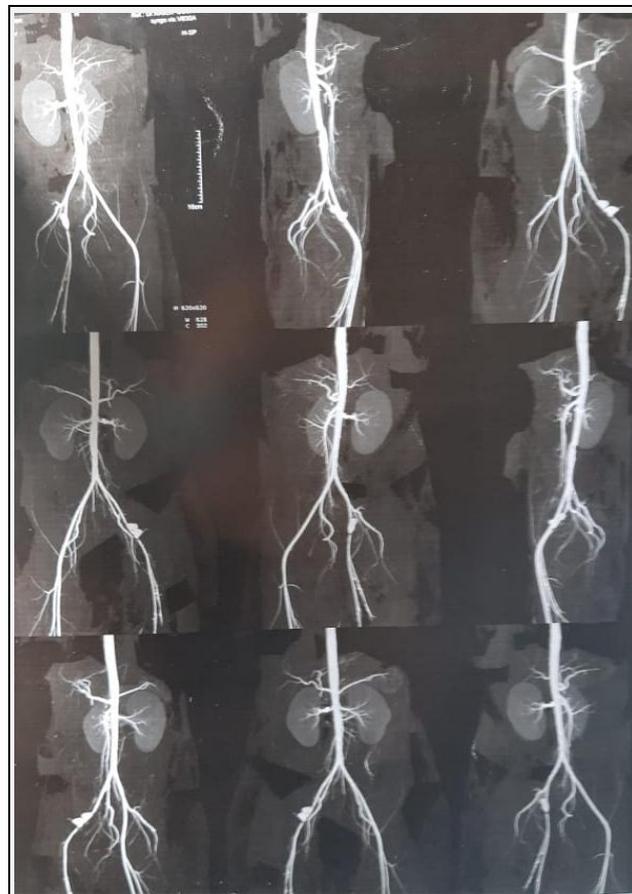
CT Angiography showing Right EIA with Two Outpouchings which are Approximately 5.8 cm and 7.1 cm from the Bifurcation of the Common Iliac Artery on its Lateral Aspect Measuring 1.5 X 1 cm and 1.6 X 1 cm
